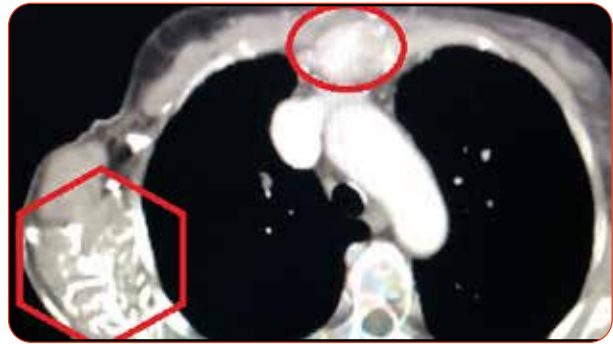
Enhanced axial CT scan showing (i) extensive destruction of right scapula (red hexagon) from spread of RCC, and (ii) destruction of sternum (red circle).
